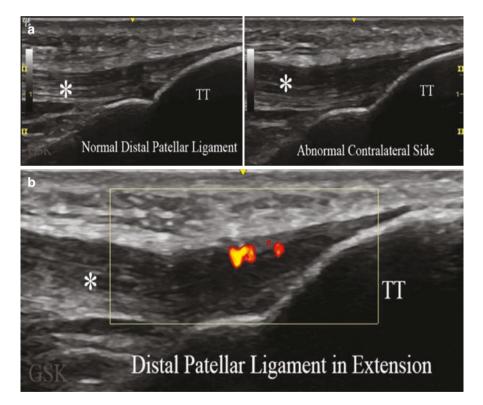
(a) Normal distal patellar ligament (asterisk) as it attaches to the tibial tuberosity (TT). Adjacent image shows patellar tendinopathy—abnormal distal patella ligament (asterisk). There are ligament thickening and loss of fibrillar echotexture. (b) Increased vascularity (neovascularity) as indicated by positive power Doppler is seen in patellar tendinopathy. Of note the knee is in extension to maximize Doppler sensitivity
